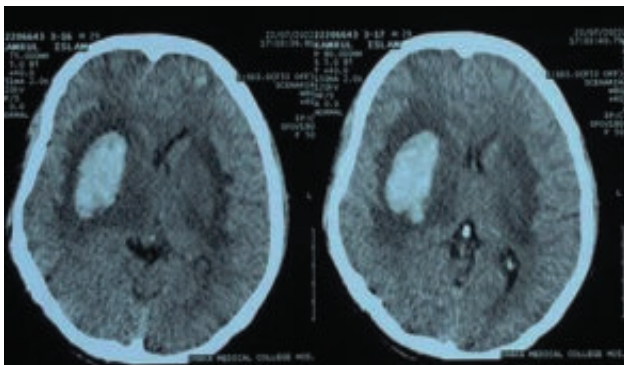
Computed tomography brain showing cerebral bleed in the basal ganglia; putamen (right>left) with midline shift.
